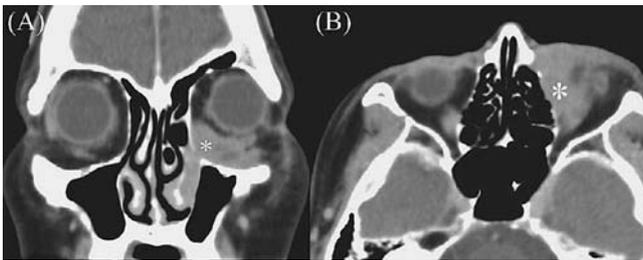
The Computed tomographic image of case 1. (A) Contrast-enhanced coronal computed tomographic image of a mass located in the left orbit extending into the ipsilateral nasolacrimal duct with slight enhancement (asterisk). (B) A contrast-enhanced axial computed tomographic image of a mass located close to the ipsilateral orbital apex with slight enhancement (asterisk).
